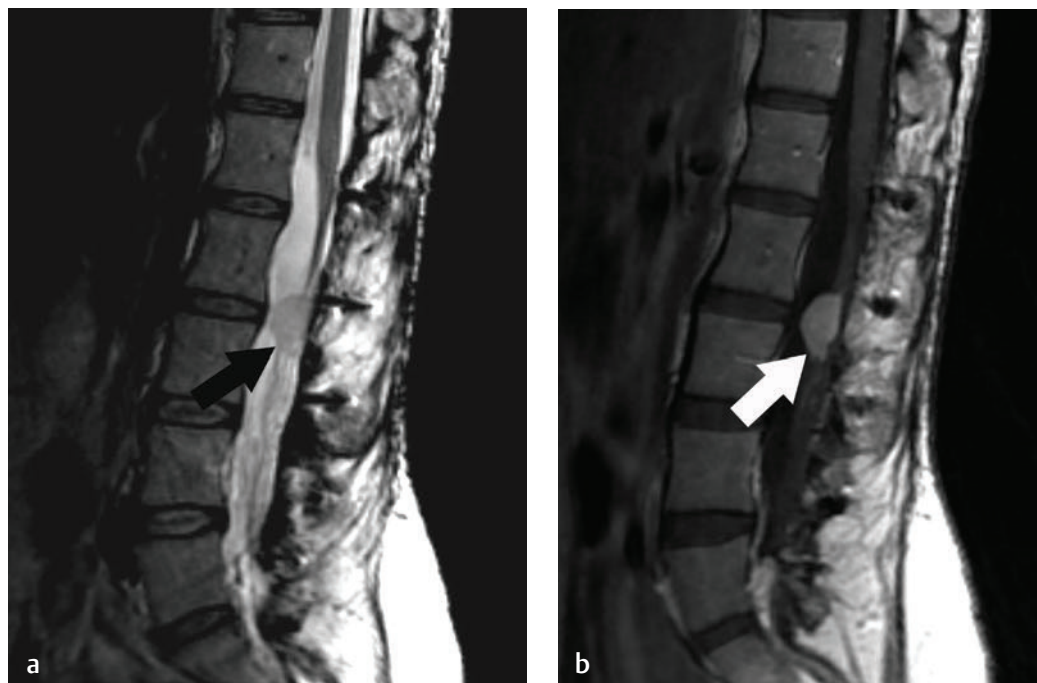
Sagittal images of a schwannoma in the lumbar spine. (a) The lesion (arrow on each) is slightly hyperintense compared with the cord on a T2-weighted image and (b) shows strong homogeneous contrast enhancement with gadolinium on a T1-weighted image.
